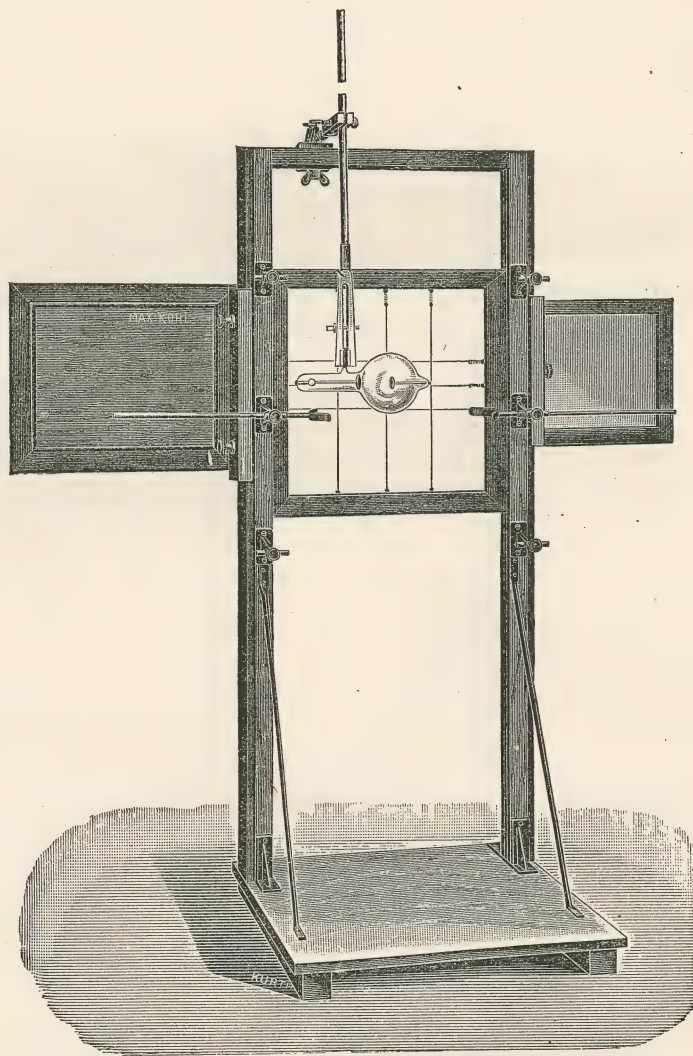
Back view of Dr. Hoffmann's measuring stand for X-ray examinations.
